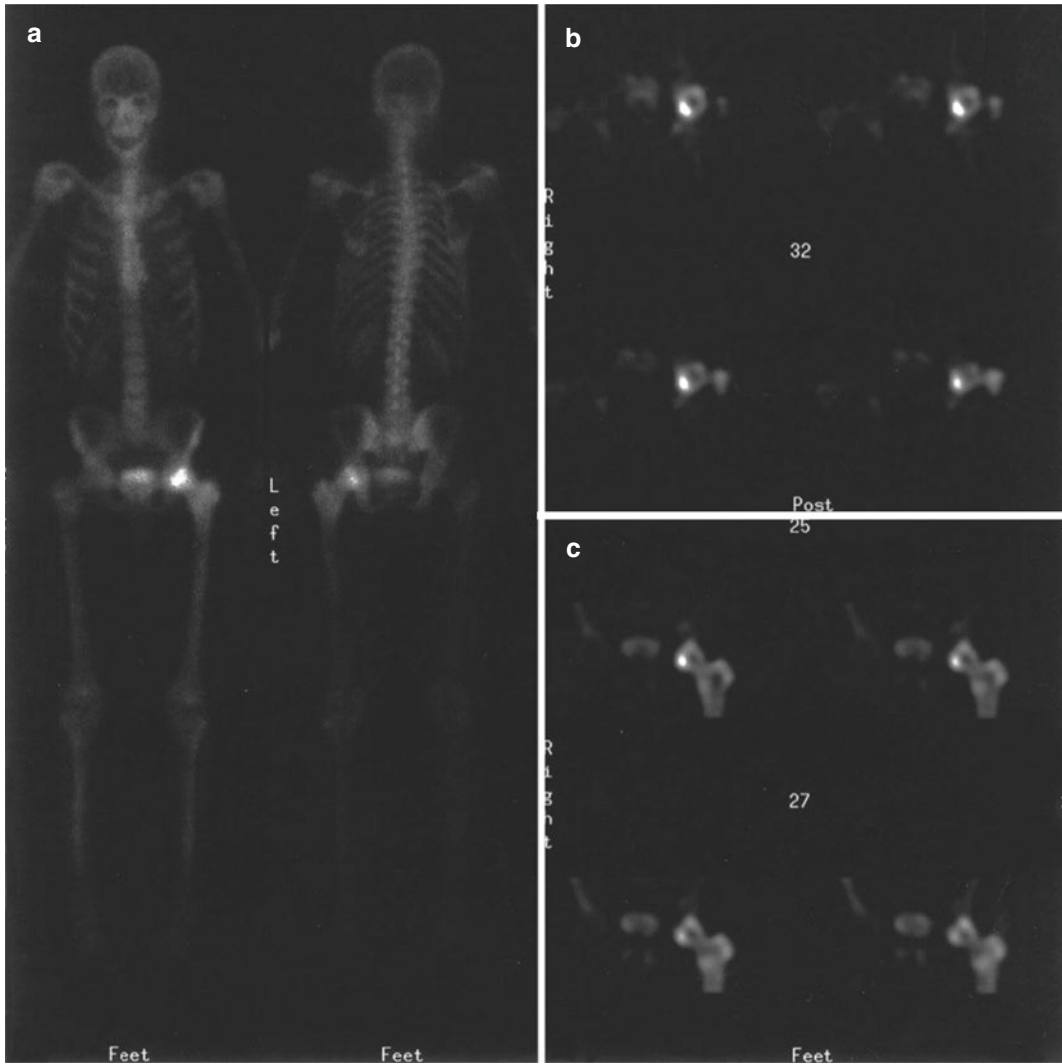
(a–c) Bone scan from a case of osteonecrosis of the femoral head. SPECT images show a central cold area, confirming the diagnosis
